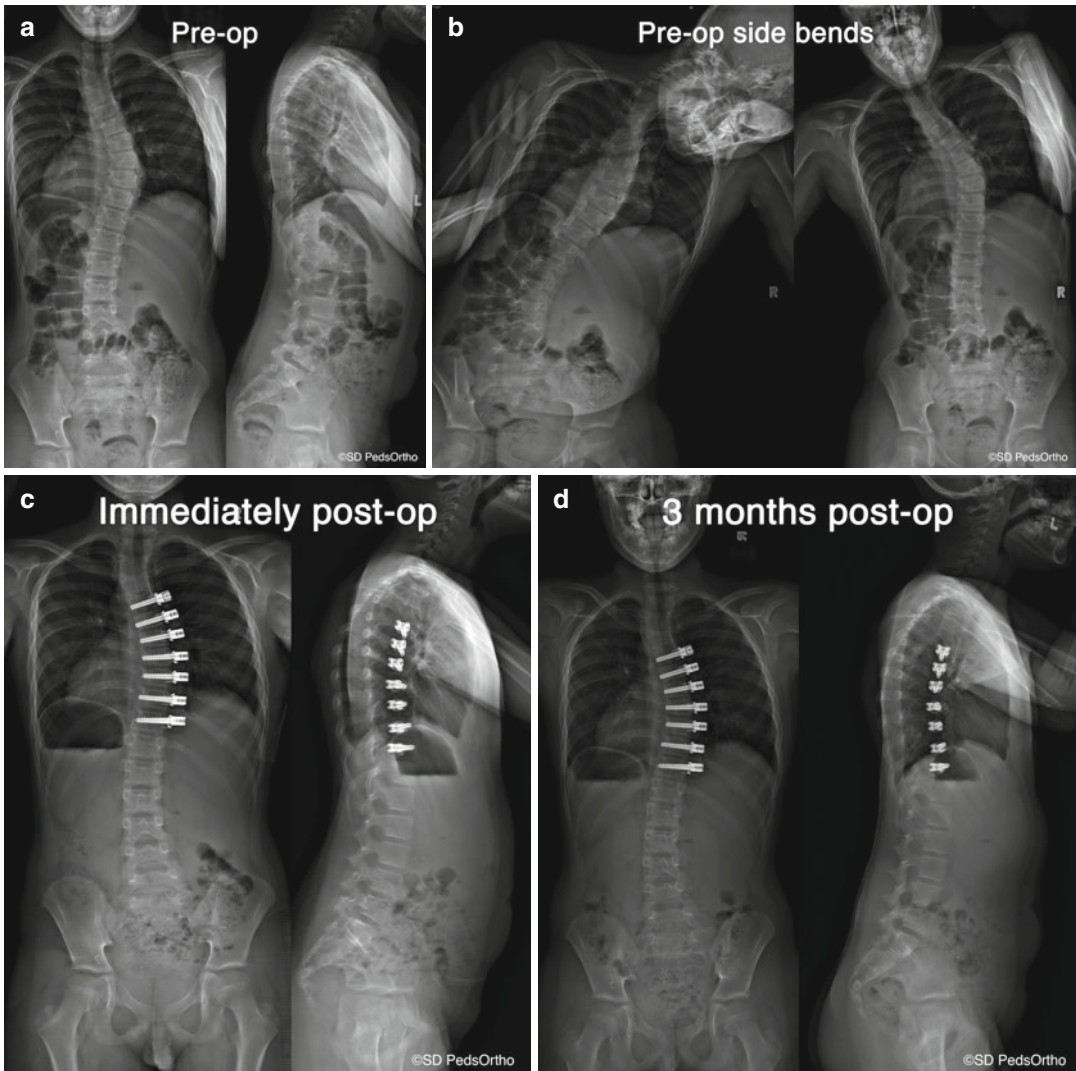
An example case of growth modulation to treat scoliosis using an anterior tether. (a) Standing preoperative PA, lateral, and (b) side-bending radiographs of a 10-year, 2-month-old boy with 44° right thoracic curve. (c) Two weeks following anterior spinal tether placement
